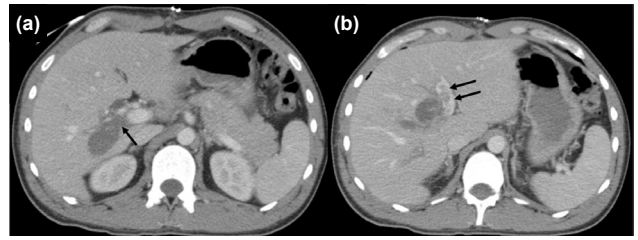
Computed tomography (CT) performed due to fluctuating jaundice following gallbladder drainage: (a) Occlusion of the right portal vein branch by thrombus (arrow). (b) Partial thrombus in the left branch (double arrows).
